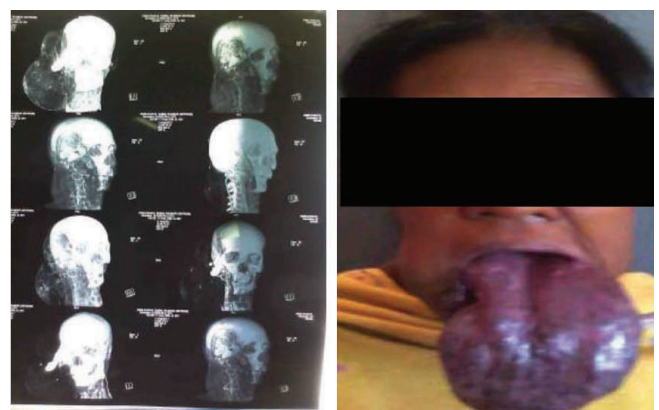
CT angio showing AVM of the Patient No. 6; Figure-8: AVM of lower lip and tongue
